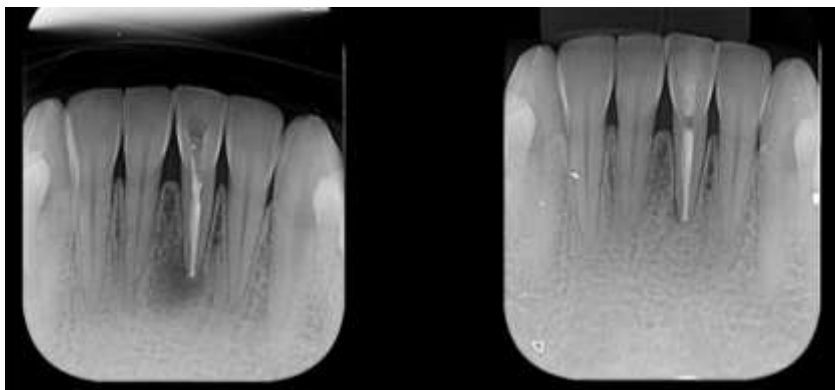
Total regression of the periapical lesion associated with the root apex of element 31 after 1 year and 7 months.
